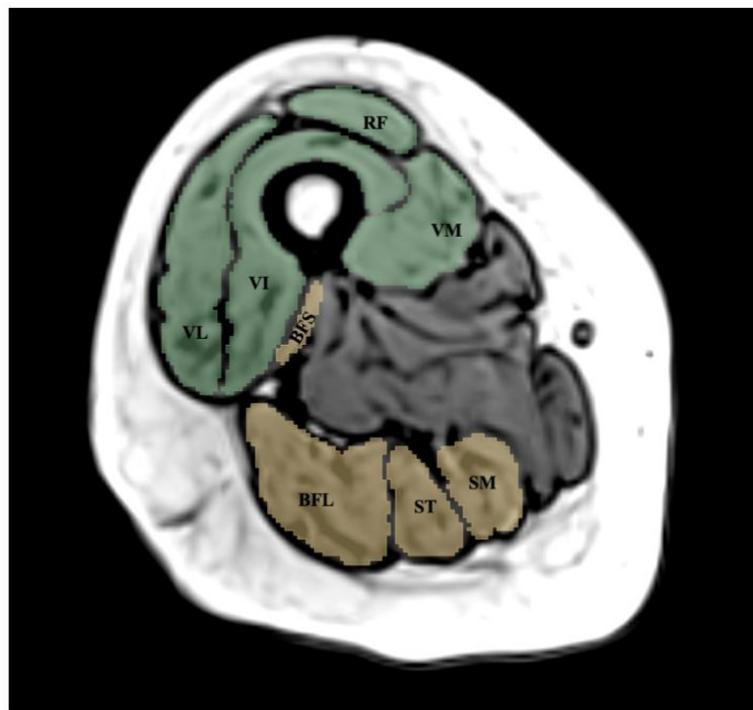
Example of MRI segmentation with muscles annotated, cross-sectional Knee extensors (green): Vastus medialis (VM), Vastus lateralis (VL), Vastus intermedius (VI), Rectus femoris (RF); Knee flexors (yellow): biceps femoris long head (BFL), biceps femoris short head (BFS), Semitendinosus (ST), Semimembranosus (SM). MRI = Magnetic Resonance Imaging.
